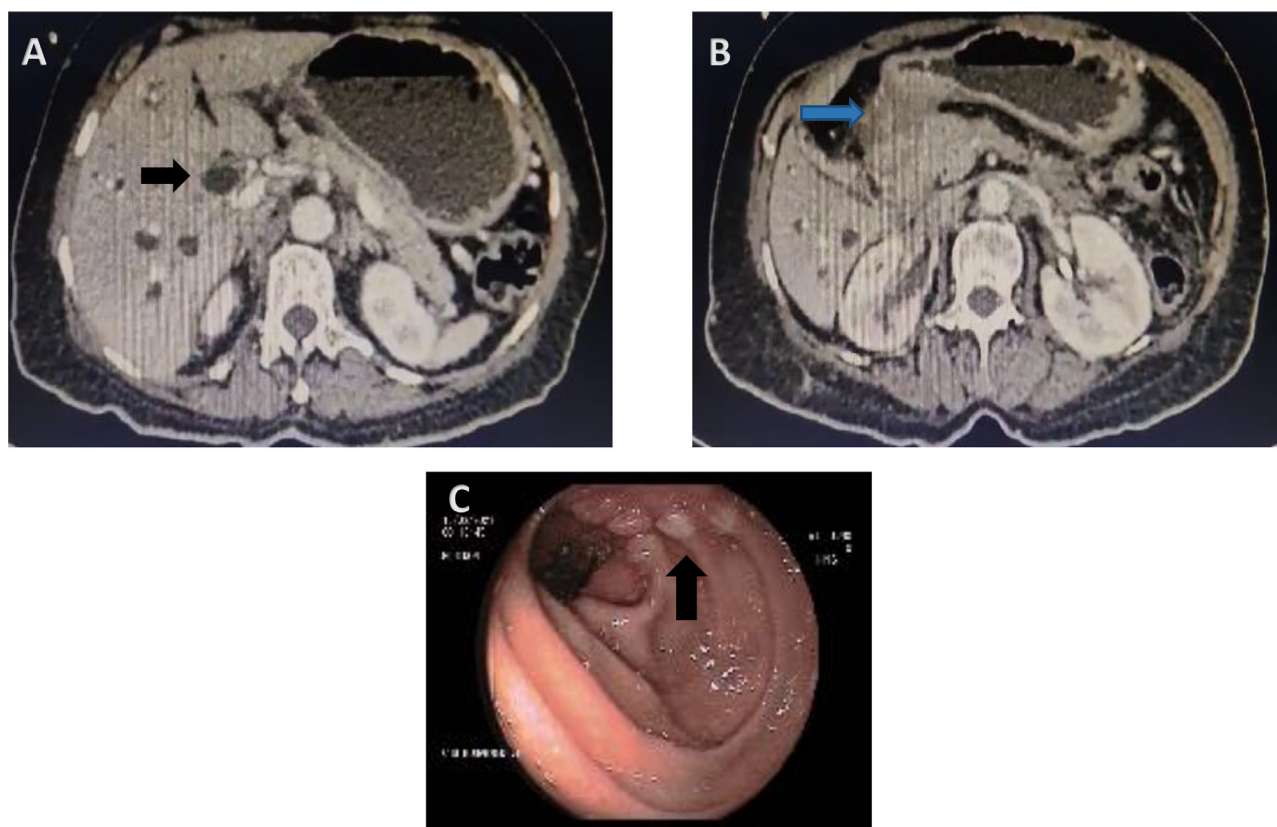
Radiology and endoscopic imaging of duodenal mass, (A) Abdominal CT scan dilatation of intrahepatic and extrahepatic bile ducts (arrow); (B) Contrast-enhanced abdominal CT scan showing irregular gastric wall thickening extending to the second part of duodenum (arrow); (C) Gastroscopy showing ulcero-budding duodenal process (arrow).
